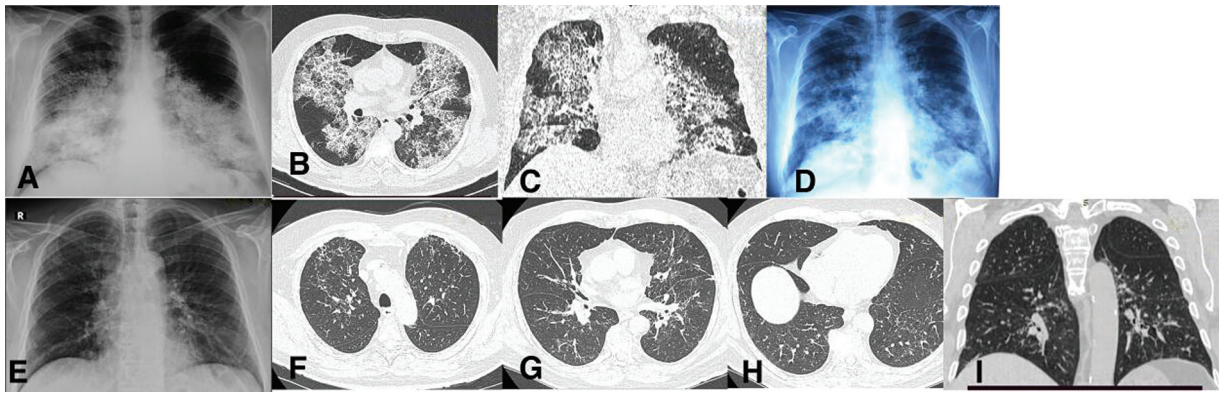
It regards a 65-year-old male heavy smoker with aPAP. (A) Chest X-ray after a rather unsuccessful WLL showing air space consolidations, bilateral, symmetrical, basal and perihilar, with relative sparing of the upper lobes. (B, C) Typical crazy paving pattern in sagittal and coronal views. (D) Chest X-ray the first few years after the initiation of inhaled GM-CSF 250 µg 4 days on 4 days off, showing a mild reduction of the pulmonary opacities, with similar distribution, slight improvement, but very slow. A daily administration treatment schedule was adopted to attain complete remission and a new regimen. (E) Chest X-ray 12 years after the initiation of inhaled GM-CSF at the de-escalation time point 2 days on 4 days off, showing almost complete resolution of the opacities with reticular opacities visible at the basis, especially on the left side. To better clarify interstitial abnormalities, an HRCT scan was performed, showing in (F–H) sagittal views and I coronal view, reticular opacities, prevalent in the middle lung zone, without peripheral or central predominance. Findings of fibrosis are minimal, and particularly, honeycombing is absent.
